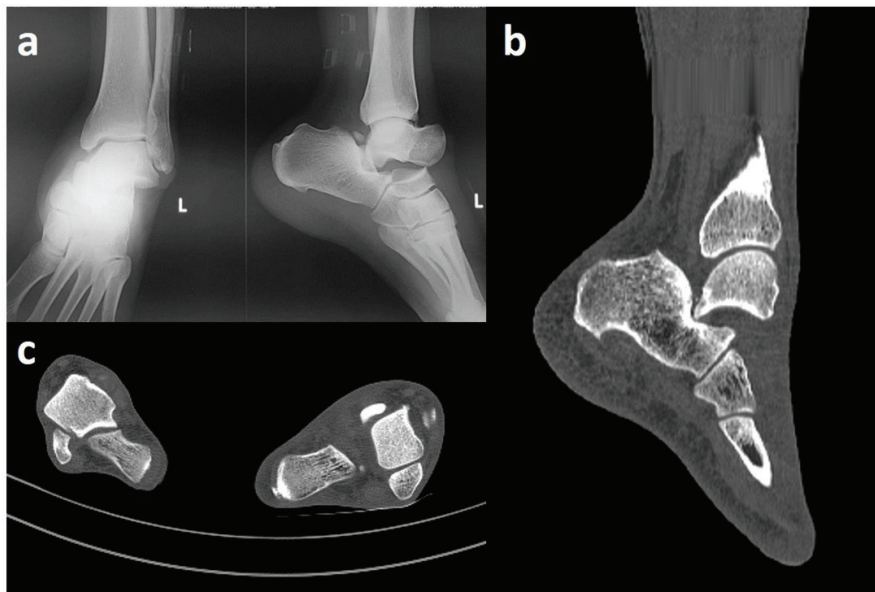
Imaging Studies (2a: Plain X-ray, 2b: Sagittal CT scan, 2c: Axial CT scan)
